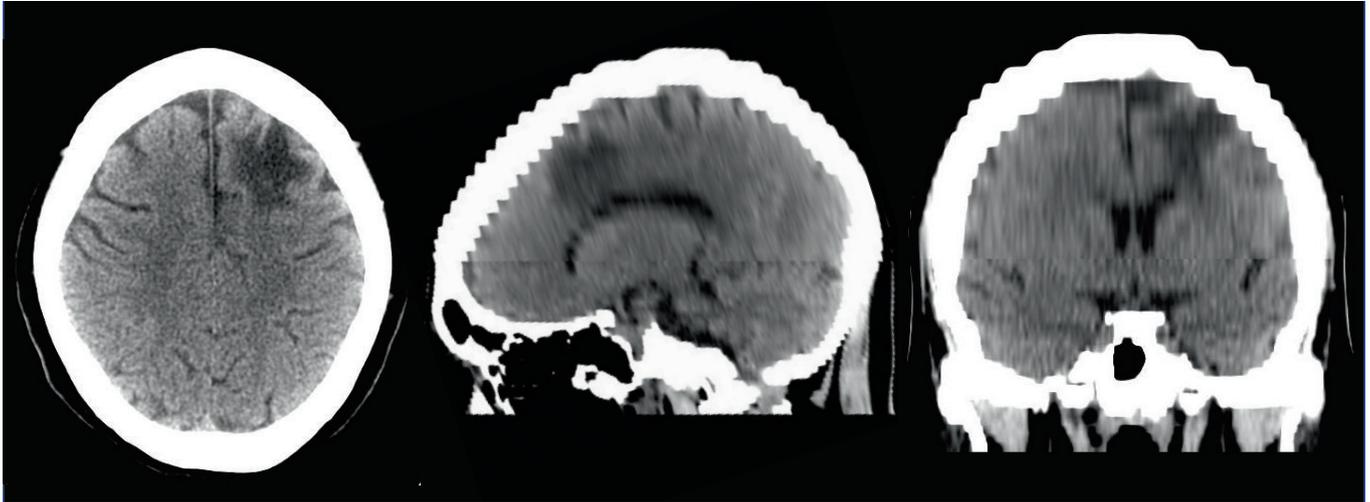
Computed Tomography (CT) imaging scan of head. It is clearly evident a large lesion in right frontal area.*
